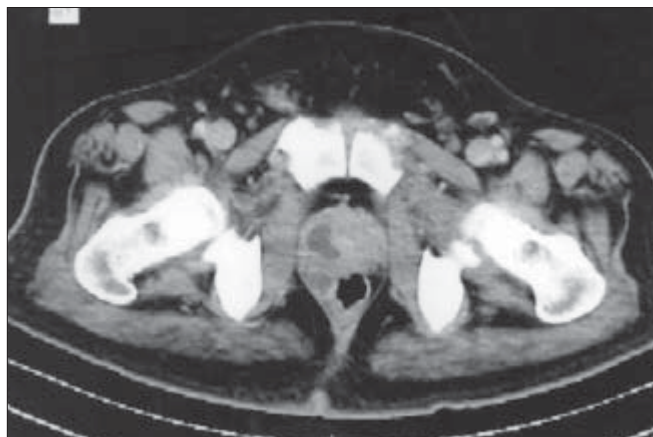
CT scan showing a low attenuating area in prostate
